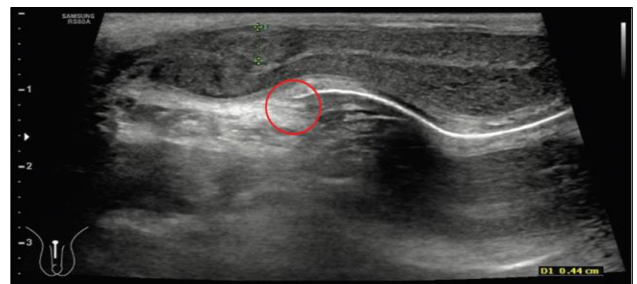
Ultrasonography of penis.
